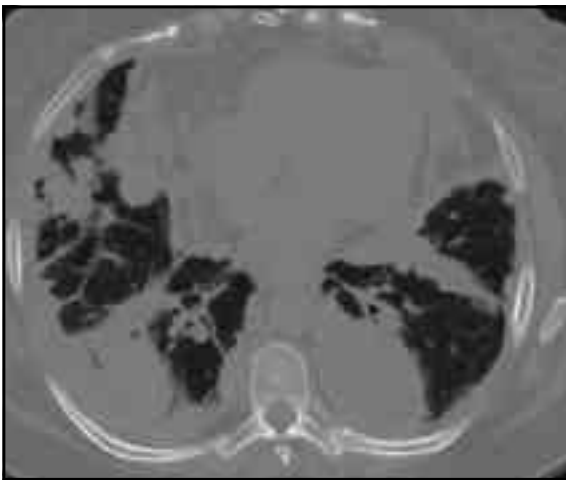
Computed tomography scan of the thorax demonstrating large consolidations at lower zones (a) and mediastinal lymphadenopathies with pleural thickening (b) .
